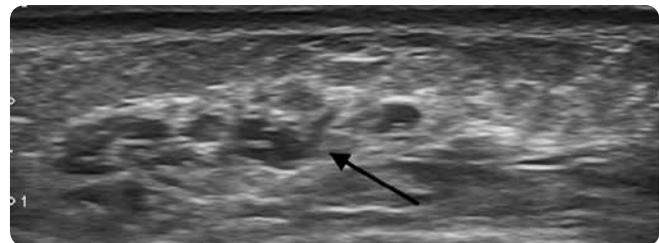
Ultrasound, axial: characteristic aspect of hyaluronic acid with pseudocystic images of well-defined edges (arrow).
